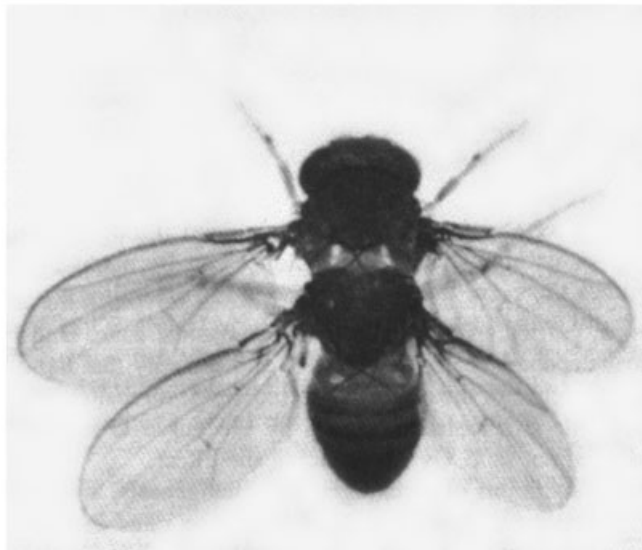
Top: normal *Drosophila* male. Bottom: *Drosophila* male with four wings resulting from one spontaneous and two X-ray induced mutations. [Source: E. B. Lewis, California Institute of Technology. Reprinted with permission from J. Marx, "Genes that Control Development," *Science* 213, 1485–1488 (1981). Copyright 1981 by the American Association for the Advancement of Science.]
